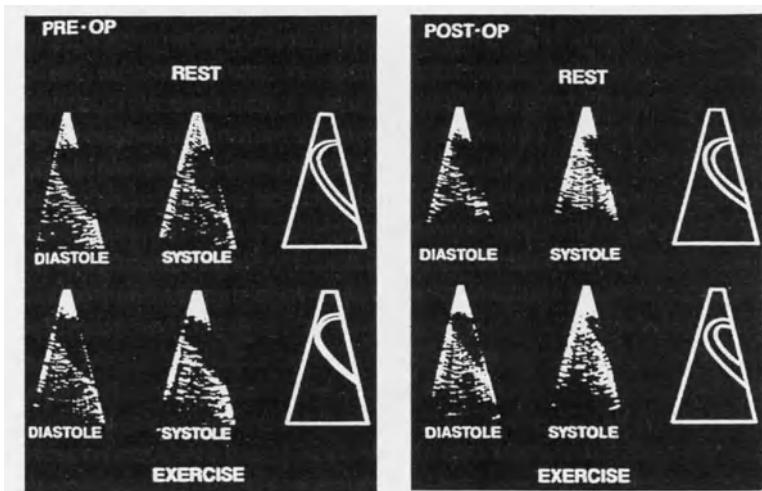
Early stress echocardiogram from the work of Wann *et al.* depicting a patient with significant coronary disease and inducible ischemia (left panels). Following successful bypass surgery there is return of normal function at rest and with stress in this individual (right panel). Reprinted with permission of the American Heart Association.
